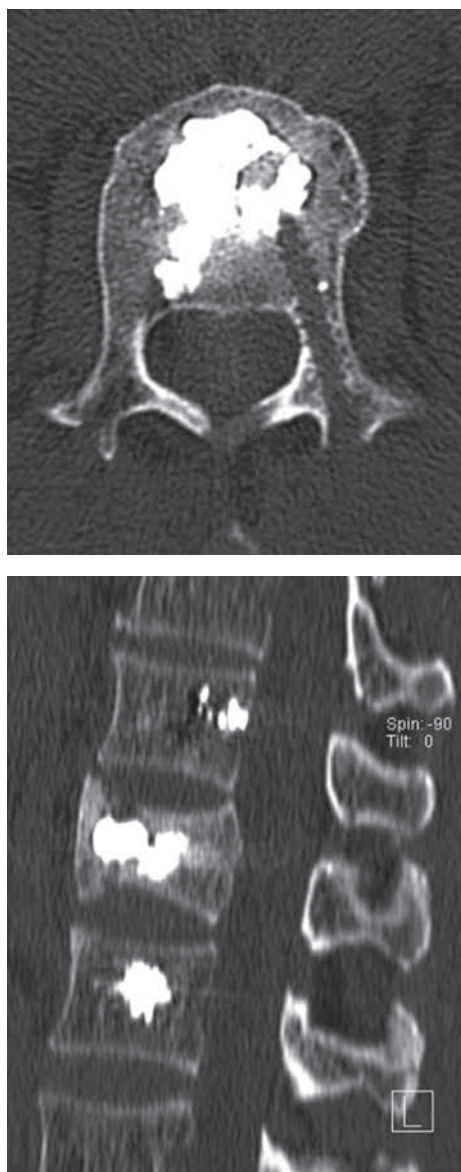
CT-scan (plain and sagittal reconstruction image) of the patient 12 months after surgery showing reduced spinal canal encroachment and excellent alignment and adequate vertebral body reduction.
